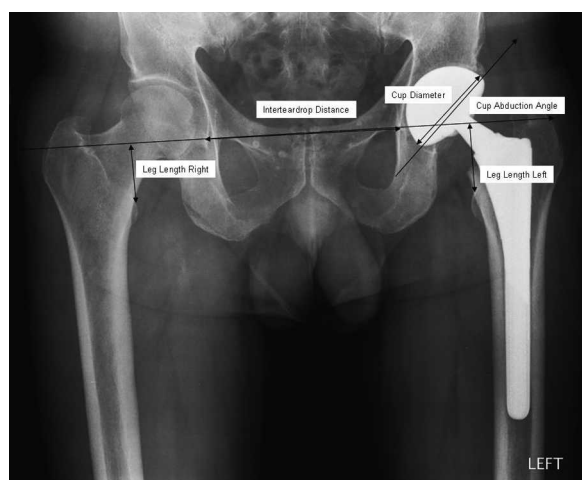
This anteroposterior pelvic radiograph shows the measurement of cup abduction and leg length change on a post-operative image.
